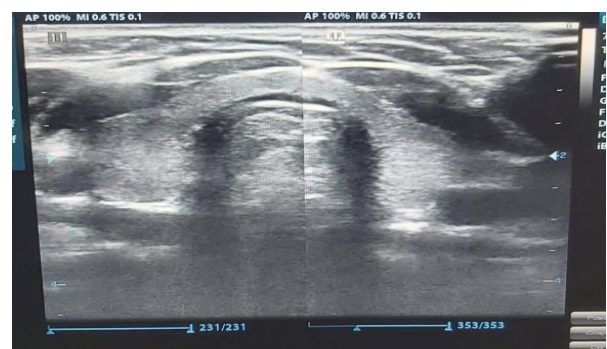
Ultrasound image of a normal thyroid gland
